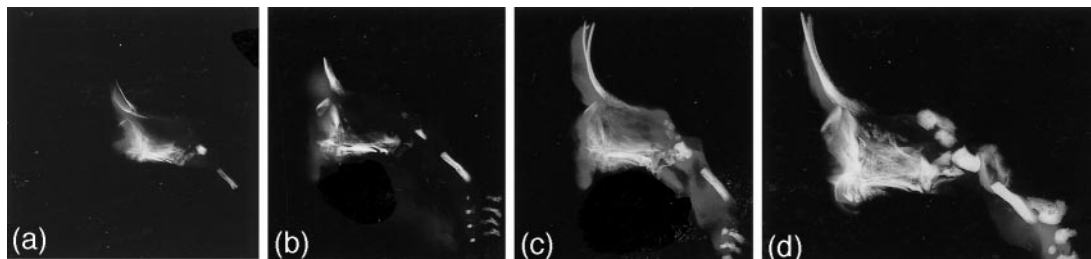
MSS radiograph showing the mid-sagittal part of the cranial base and the maxillary complex of Turner syndrome fetuses ($\times 1$). (a) MSS IV, GA = 17 weeks, CRL = 120 mm, TNO = 29/3, cranial base angle n-s-ba = 141, maxillary prognathism s-m-sp = 85. (b) MSS V, GA = 18 weeks, CRL = 138 mm, TNO = 29/3, cranial base angle n-s-ba = 146, maxillary prognathism s-m-sp = 84. (c) MSS V, GA = 18 weeks, CRL = 145 mm, TNO = 29/3, cranial base angle n-s-ba = 147.5, maxillary prognathism s-m-sp = 84. (d) MSS VI, GA = 22 weeks, CRL = 220 mm, TNO = 31, cranial base angle n-s-ba = 143.5, maxillary prognathism s-m-sp = 81.5.
